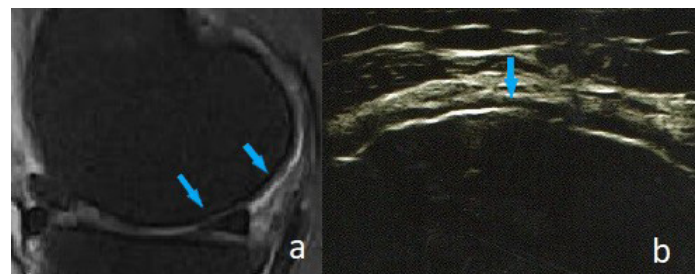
Coronal, fat suppressed, proton density weighted knee MRI (a) and transverse US (b) images of a 20 years old male patient. We see in both images that femoral articular cartilage integrity is protected.
